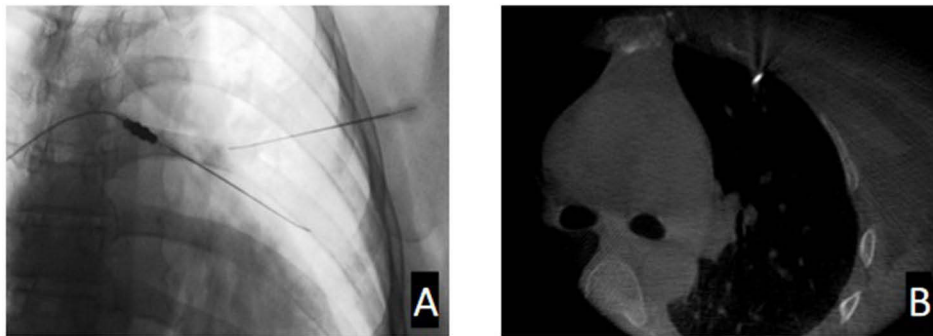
Incorrect intrathoracic cannula placement detected by O-arm CT. (A) X-ray of the cannula position. (B) 3D CT of the cannula position.
